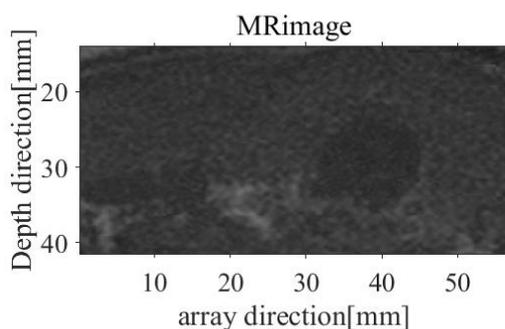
MR image of the human neck.
